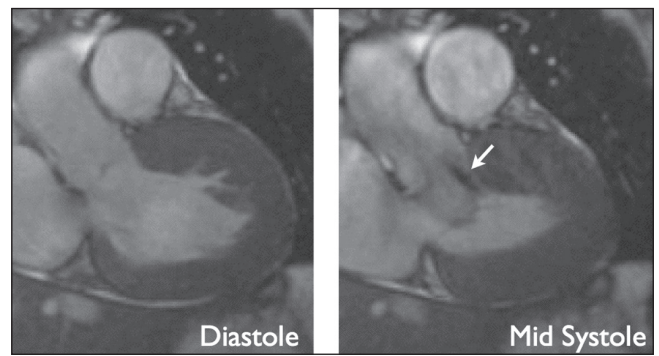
A patient with hypertrophic obstructive cardiomyopathy. Both images are extracted from functional steady-state free precession cine movies, at diastole (left) and mid-systole (right). The diastolic image displays marked thickening of the anterior septal wall. At mid-systole, there is an anterior movement of the anterior mitral valve leaflet, causing left ventricular outflow tract obstruction and a jet of high-velocity flow (arrow). Cardiovascular magnetic resonance imaging allows for quantification of the obstruction by planimetry of the left ventricular outflow tract and flow velocity quantification of the jet (not shown)
